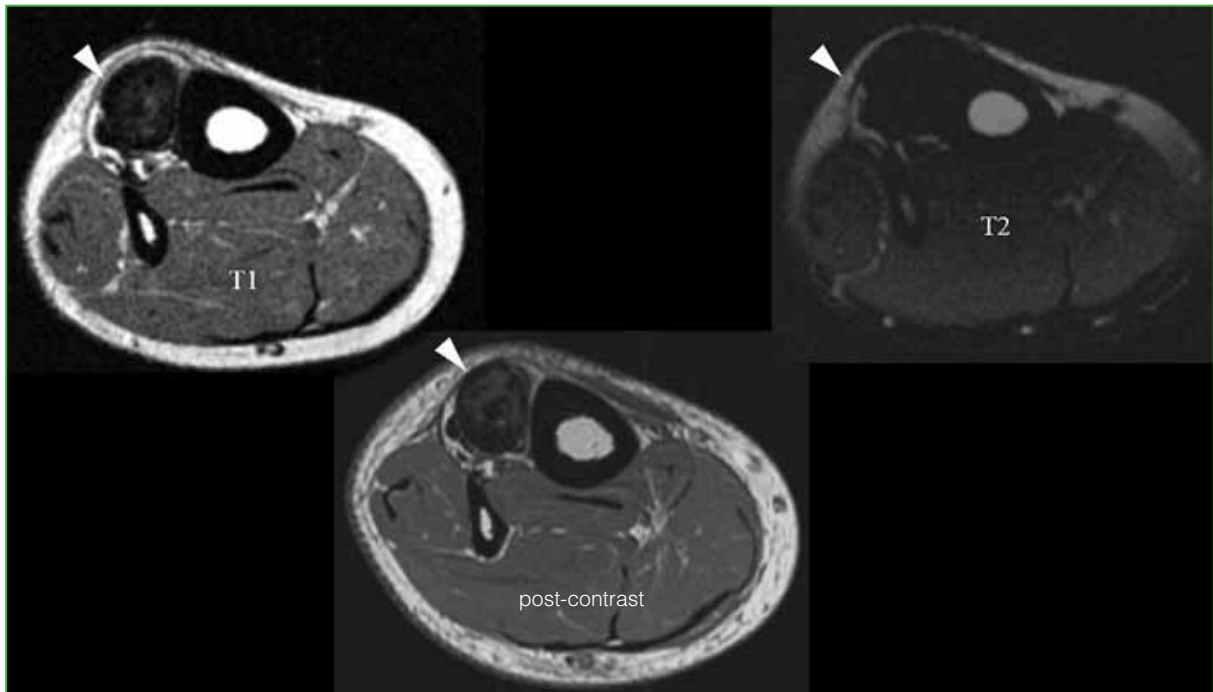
MRI of the leg with contrast medium. In the T1- and T2-weighted sequences, a low signal image is observed adjacent to the tibial shaft with little post-contrast enhancement.
